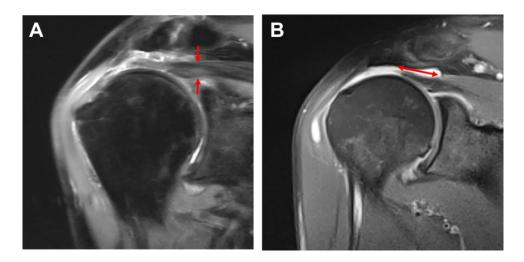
Tendon measurements on T2-weighted coronal oblique images. (A) The distance between the red arrows is the coronal oblique tendon thickness. (B) Remnant tendon length was measured as the distance between the retracted tendon end and the most lateral insertion point of the muscle fibers (double-ended red arrow).
